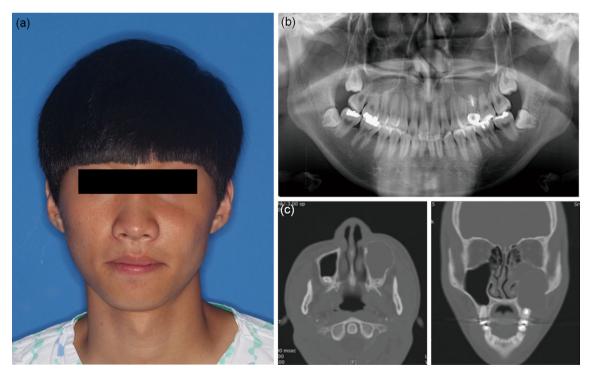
a Preoperative clinical photograph showing bulging mass on his left cheek and b panoramic radiograph showing a well-defined radiolucent lesion in the left maxilla. c Computed tomographic
